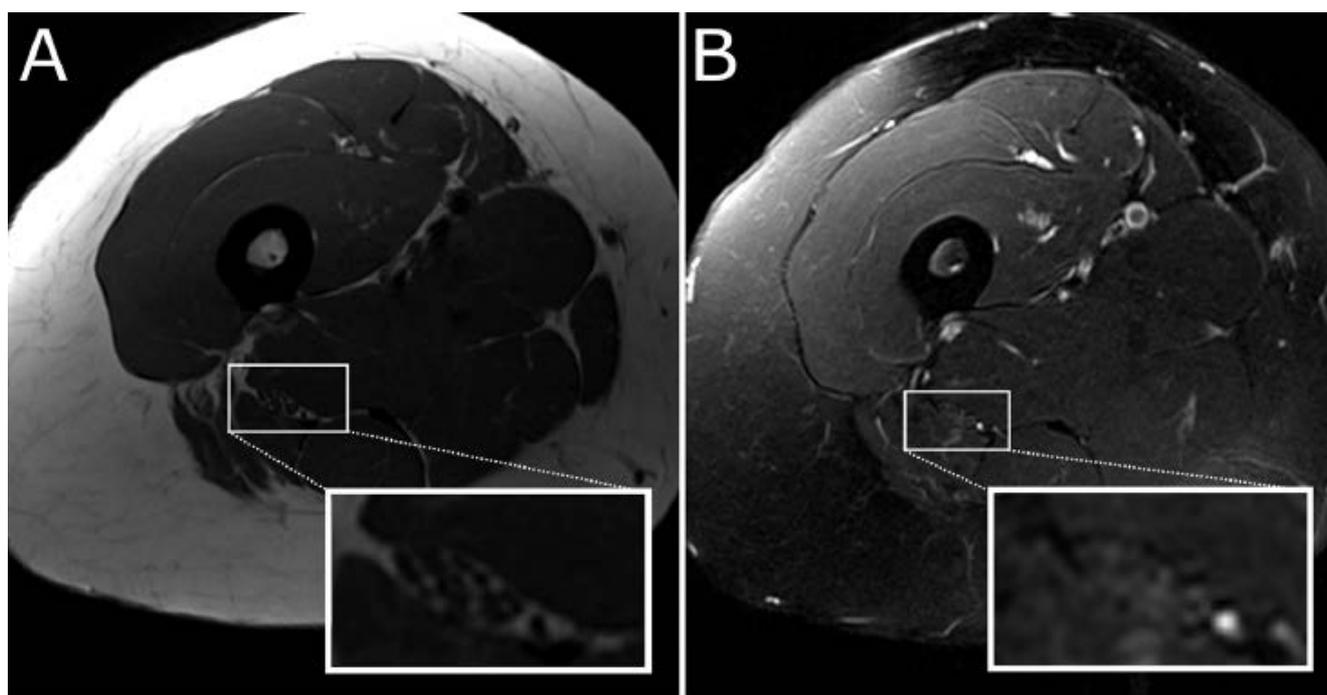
Normal MRI appearance of the sciatic nerve. On the T1-weighted image (A), the sciatic nerve is well visualized as a collection of individual hypointense fascicles surrounded by hyperintense perineural fat. On the T2 fat saturated image (B), the nerve is isointense to minimally hyperintense to the adjacent muscle. The bright focus medial to the nerve is a small adjacent vessel.
